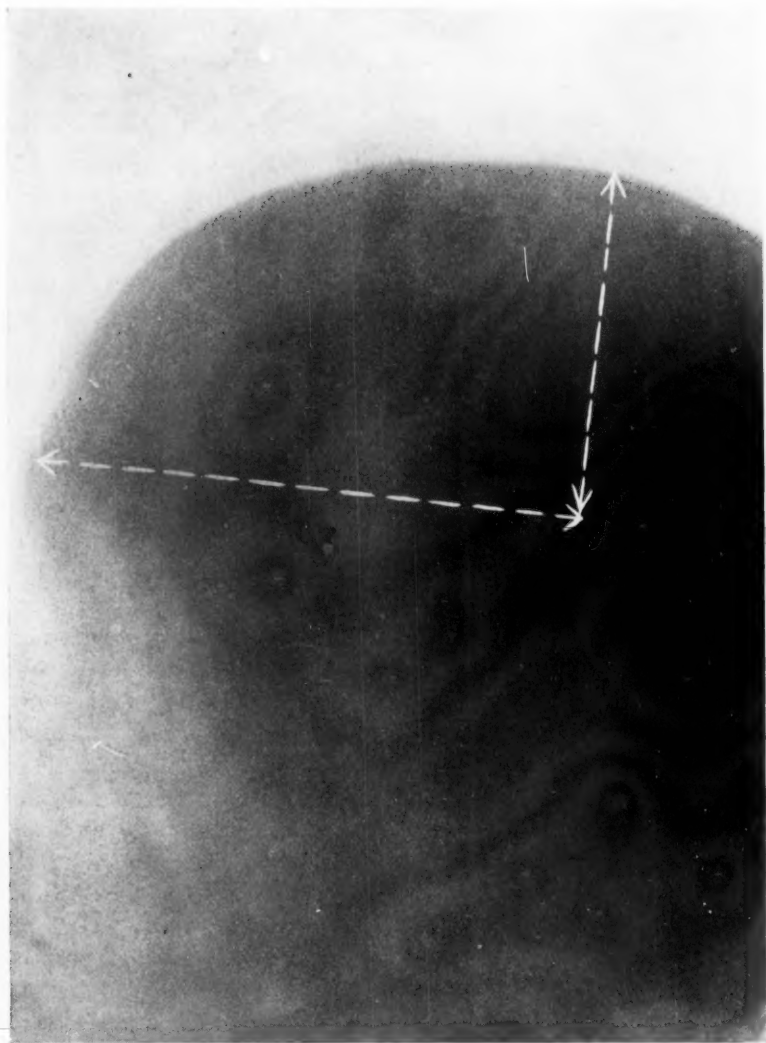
Bullet. $\left\{ \begin{array}{l} 5\frac{1}{4}'' \text{ posterior to frontal eminence.} \\ 3\frac{1}{8}'' \text{ below the vertex.} \end{array} \right.$ Radiograph by J. E. Roberts, M.D.
